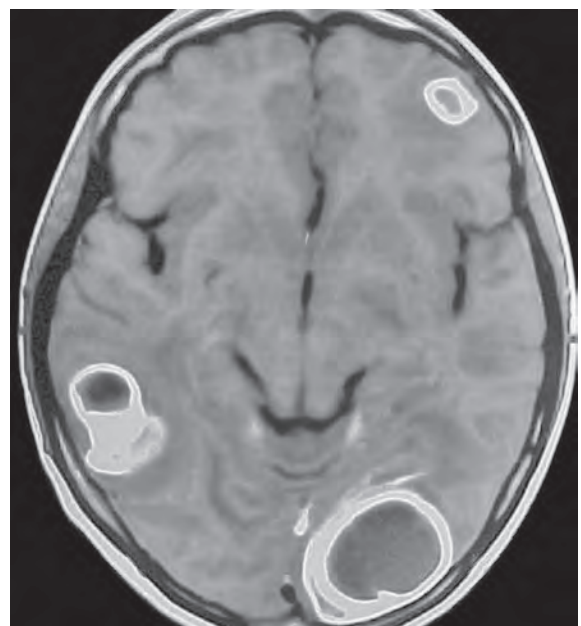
Post-contrast MRI of the brain showing multiple ring enhancing lesions of various sizes in both hemispheres
